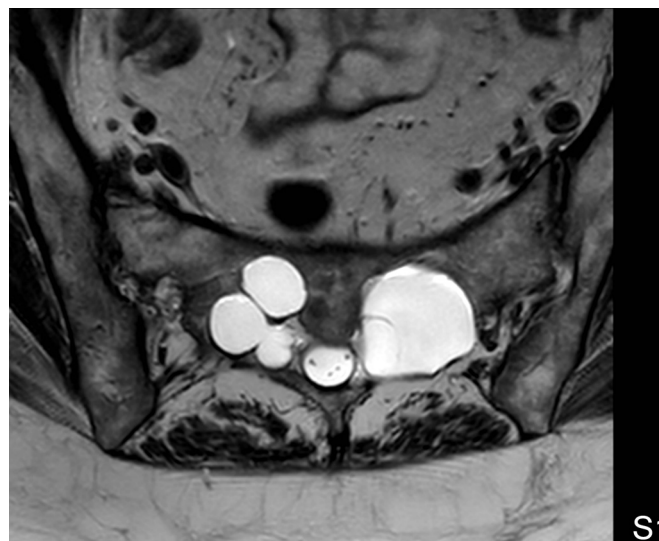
MRI Axial cut at S1 Level.
